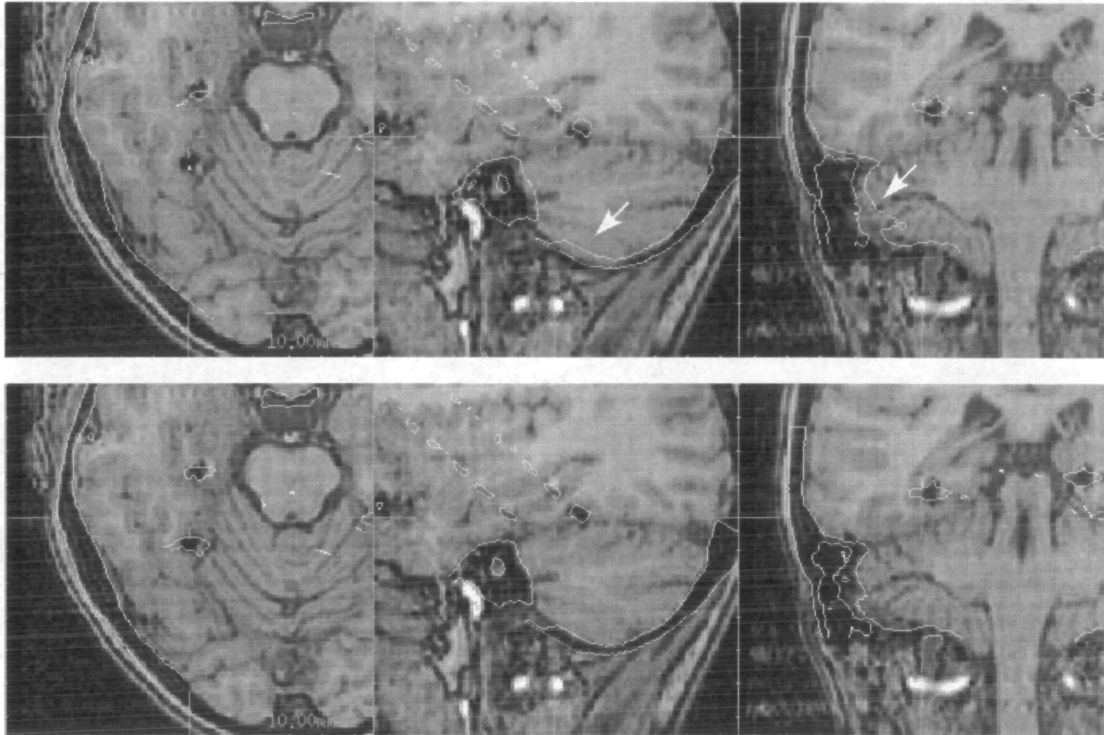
Axial, sagittal and coronal slices through solutions for image pair G: An example where the estimate provided by automated registration (bottom) is visually superior to that provided by manual point based registration (top). White arrows indicate regions of misaligned bone contour from CT.
